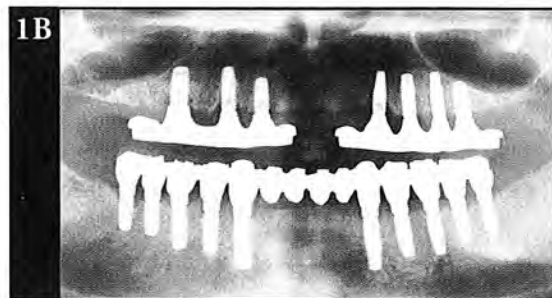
A 3-year postoperative radiograph demonstrates the integration of implant-supported restorations in both jaws.
